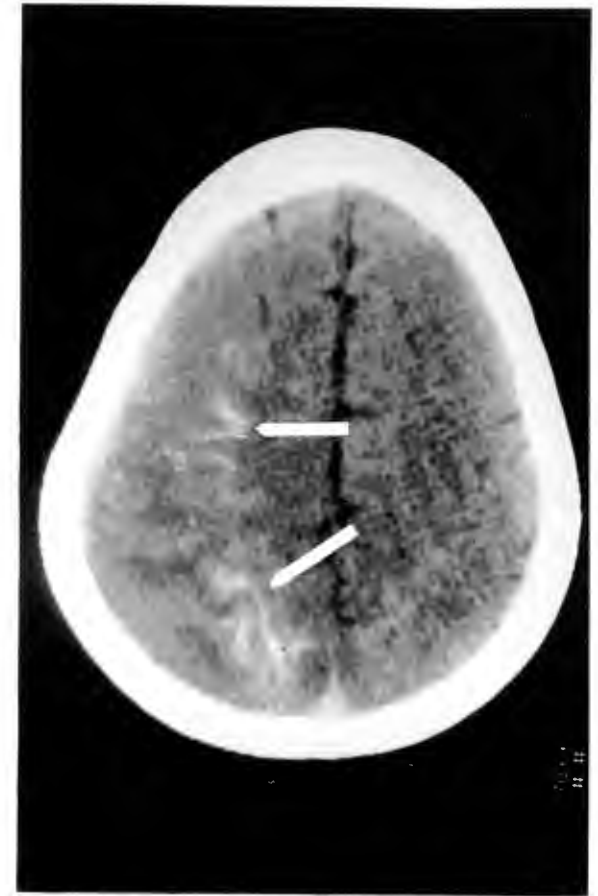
CT scans of patient No. 332/92. A) Acute scan: Diffuse brain swelling with generalised hypodensity, loss of gray/white matter differentiation, but preservation of the basal ganglia and the cerebellum. B) Convalescent scan: Cerebral atrophy with hypodense areas, suggestive of infarction in the left frontal and parietal regions (arrows).
